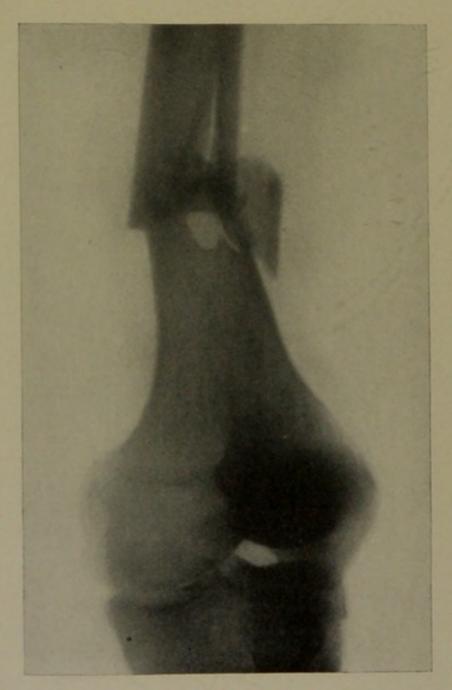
Left leg. X-ray taken October 29, 1912.
